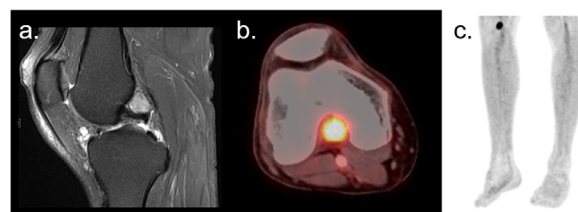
Tenosynovial giant cell tumor (localized type). (A - C) 43 y/o female with TGCT of the right knee. (A) T1 post-contrast shows significant contrast media enhancement in a well-circumscribed soft tissue nodule within the posterior joint space. (B) Fused ^{18}F -FDG PET/CT and (C) ^{18}F -FDG PET MIP show corresponding intense ^{18}F -FDG uptake.
